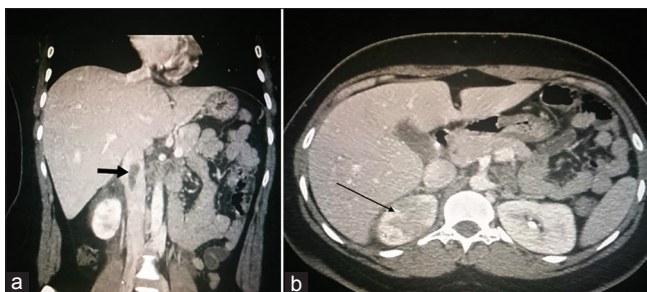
(a and b) Computed tomography showing large floating thrombus in the juxtarenal inferior vena cava, see arrow. The right kidney pyelonephritis, see arrow
